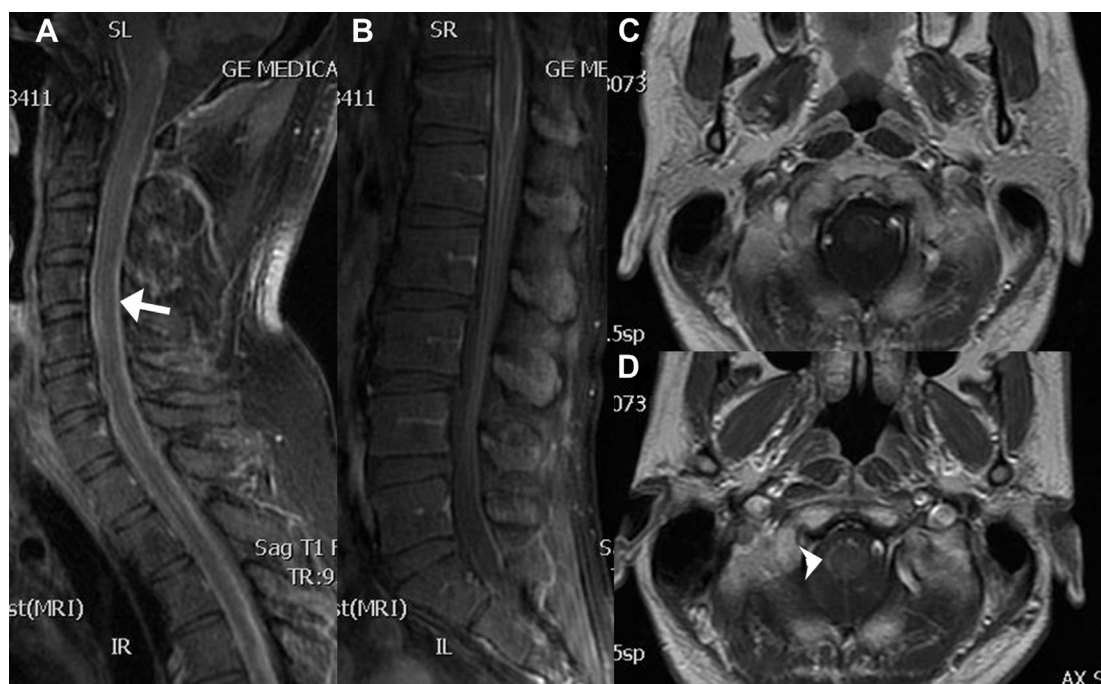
Postcontrast T1-weighted MR images of the cervical (A) and lumbar spine (B) demonstrating subarachnoid and leptomeningeal enhancement (arrow). Postcontrast axial T1-weighted MR images of the brain taken upon patient presentation of back pain, showing an enhanced lesion (arrowhead) surrounding the medulla oblongata (D), which can be compared with images obtained after 5-month adjuvant chemotherapy (C).
